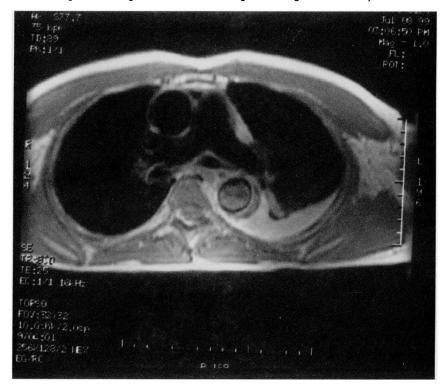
Magnetic resonance image showing aortic dissection and left-sided pleural effusion.
